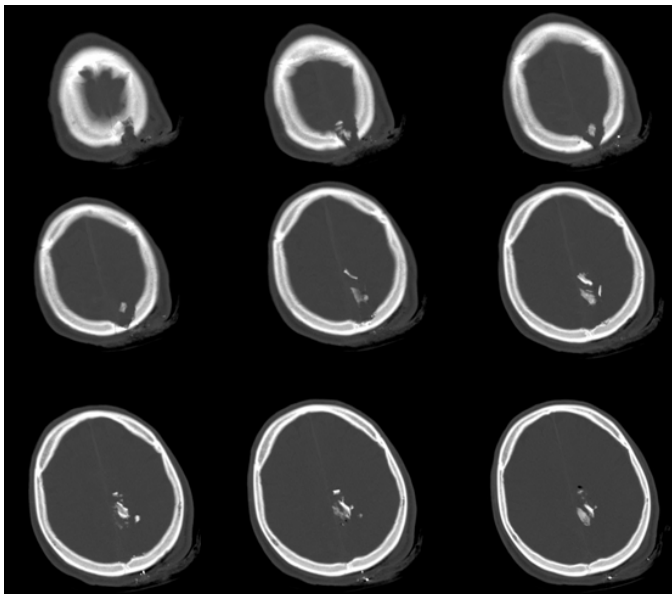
Resultant fragments shown on sequential bone window CT axial scans.
